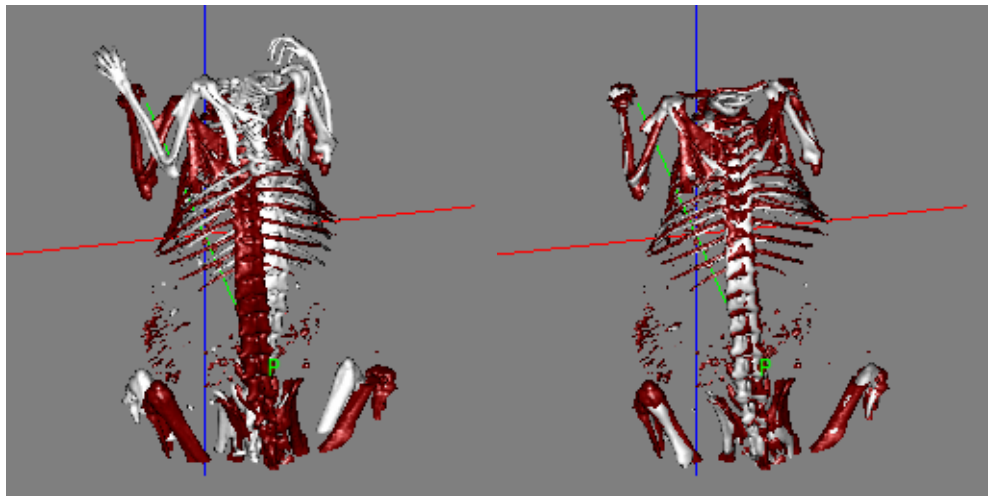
Bony structures in two micro CT volumes before registration (left) and after registration (right).
